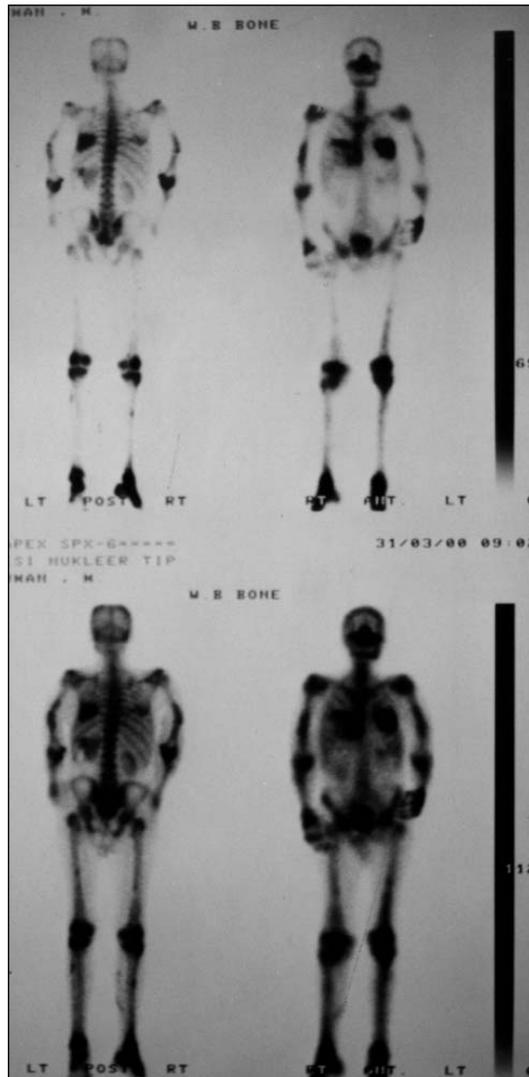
The bone scintigraphic scan showing the high uptake areas.
